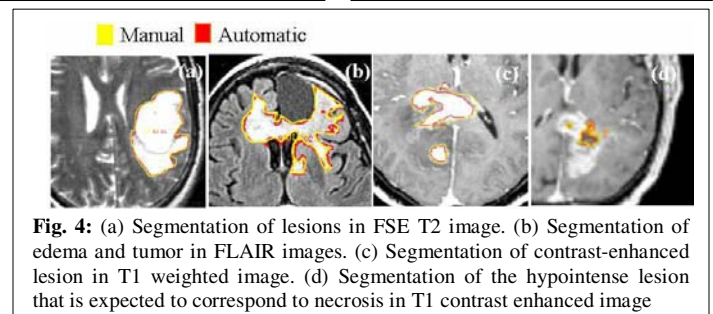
(a) Segmentation of lesions in FSE T2 image. (b) Segmentation of edema and tumor in FLAIR images. (c) Segmentation of contrast-enhanced lesion in T1 weighted image. (d) Segmentation of the hypointense lesion that is expected to correspond to necrosis in T1 contrast enhanced image
